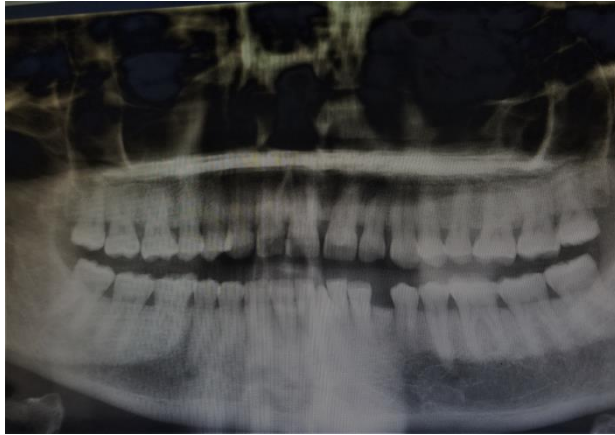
Orthopantomogram of the patient
